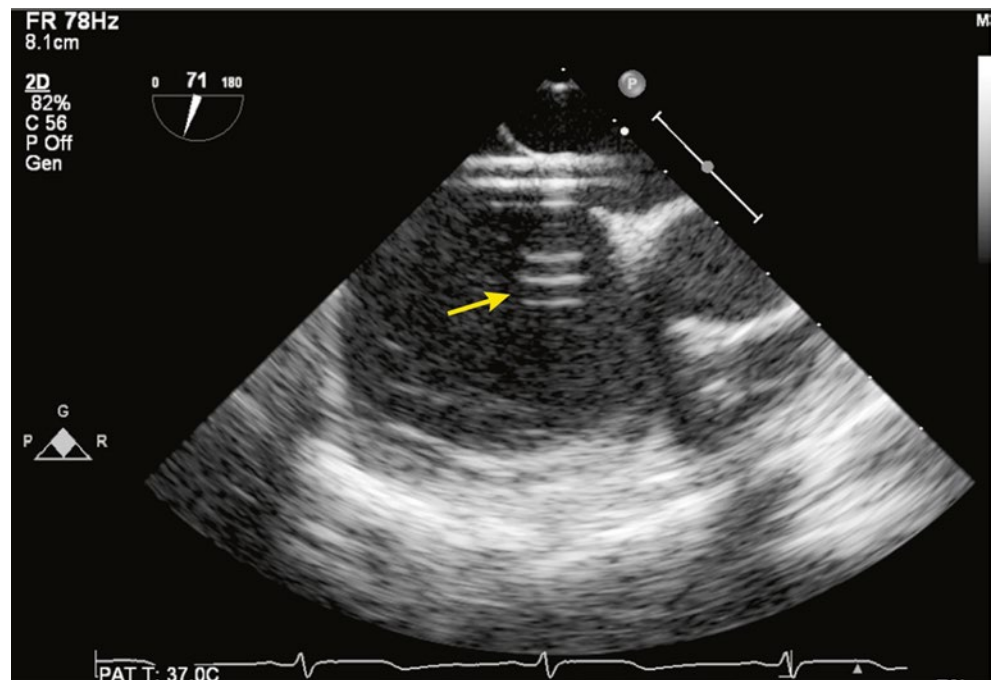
Example of a reverberation artifact in a patient undergoing transcatheter closure of an atrial septal defect. The catheter sheath in the left atrium presents a large impedance mismatch; at the points perpendicular to the ultrasound path, reverberations are seen (arrow)
